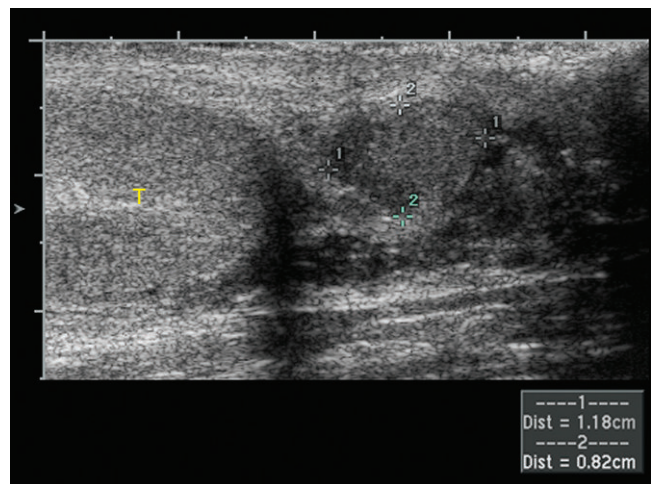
Ultrasound of the scrotum in another patient shows an extra-testicular mass (calipers) within the epididymis. (T=testis.)
